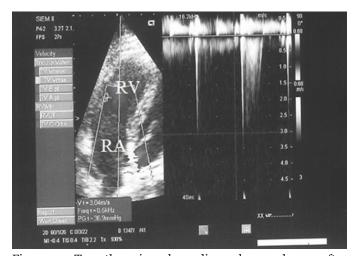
Transthoracic echocardiography 24 hours after thrombolytic therapy. [RV Right ventricle, RA Right atrium]
